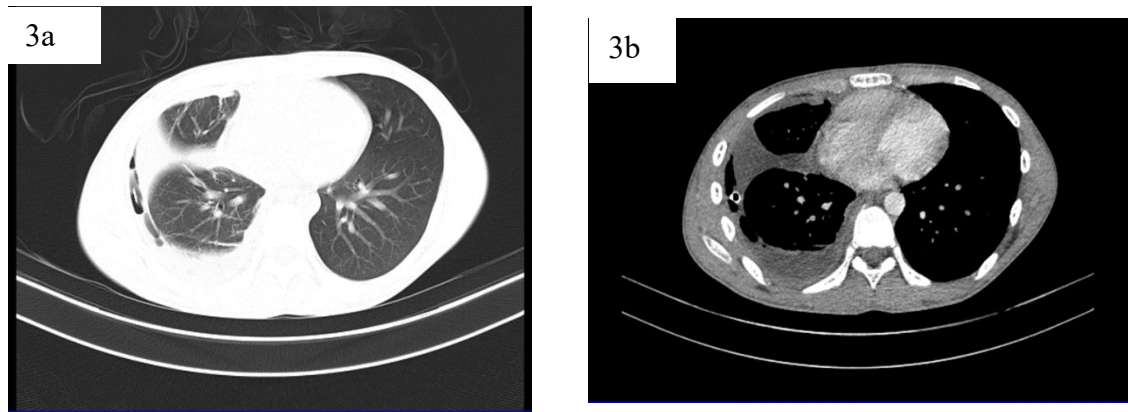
CT scan showing right pleural effusion and right pulmonary fibrosis. 3a) CT scan with lung window showing a shadow of fibrosis in the right pleura. 3b) Mediastinal window.
